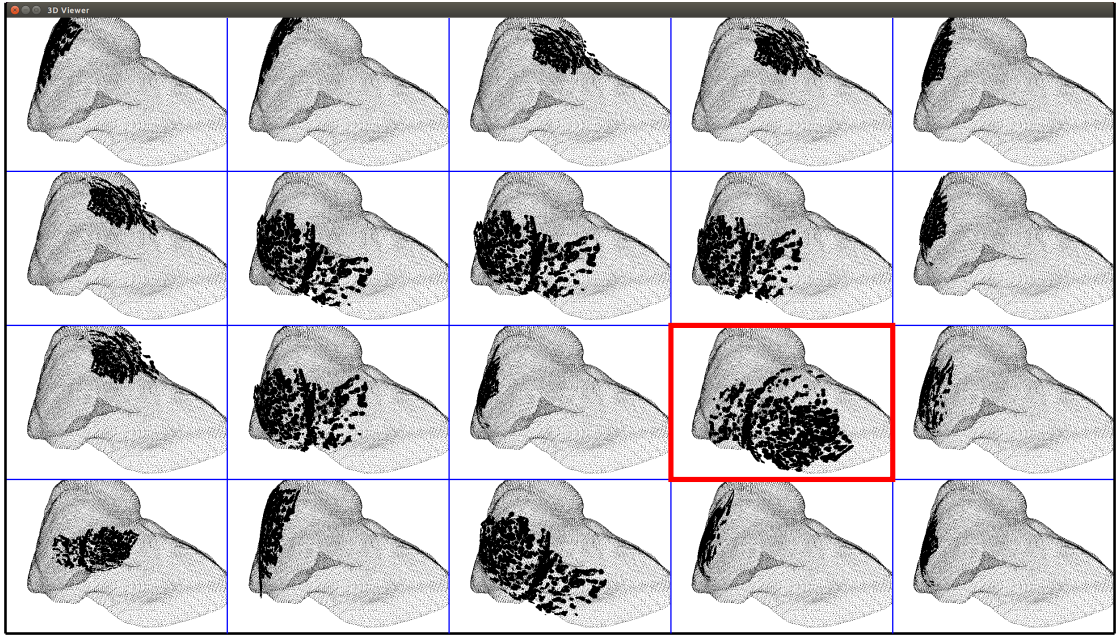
Globally Optimal Iterative Closest Point (GO-ICP) Candidate Selection Interface. The top 20 registration candidates are displayed on a 4×5 grid. The best registration candidate is selected by the user and is highlighted in red. The user is able to manipulate the view of all registration candidates in a synchronized manner (i.e., the *CT* scans common to all registration options will all have the same orientation to the camera when the view is manipulated).
